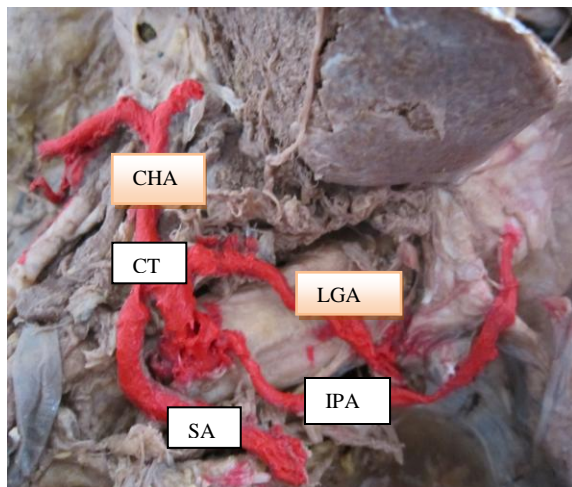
showing Quadrifurcation of celiac trunk. CT-coeliac trunk, LGA-left gastric artery, IPA- inferior phrenic artery, CHA-common hepatic artery.
